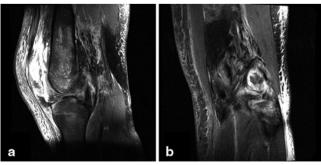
Magnetic resonance imaging of a patient who sustained an acute complete tear of the PCL off the femur (a) and a patient with a concomitant PLC injury in the presence of an acute PCL tear (b).
